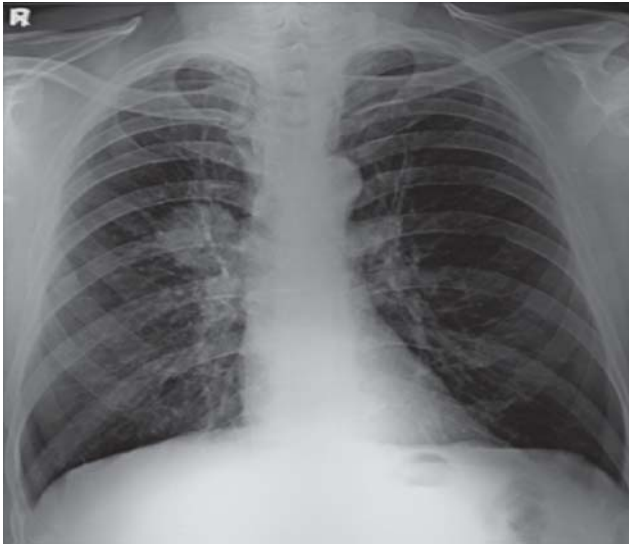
Chest radiograph (posterior-anterior view) showing right para-hilar mass.
